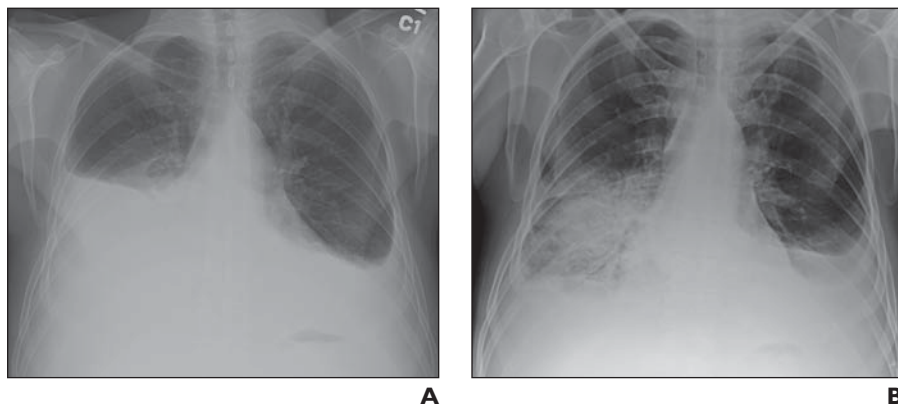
69-year-old man with extrapleural hematoma. A, Magnified anteroposterior chest radiograph performed immediately after placement of small-bore pleural drainage catheter for evacuation of pneumothorax shows no evidence of complications. B and C, Sequential magnified anteroposterior chest radiographs performed next day show development of extrapleural hematoma (*arrows*, B), which increased in size, causing opacification of left hemithorax (C). Chest tube was placed. D, Axial CT image shows large hyperdense extrapleural hematoma (*asterisk*). Note medial displacement of extrapleural fat (*arrows*).
